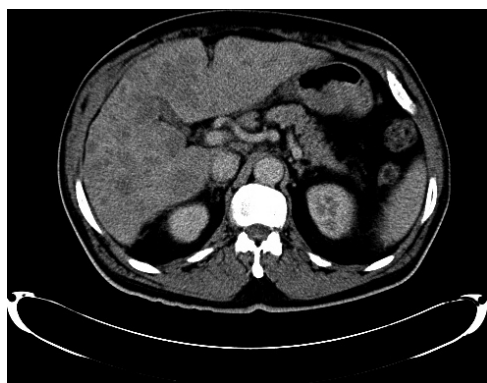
CT scan of the abdomen shows gastric wall thickening, several lymph nodes, and liver extensively replaced with metastatic disease.
